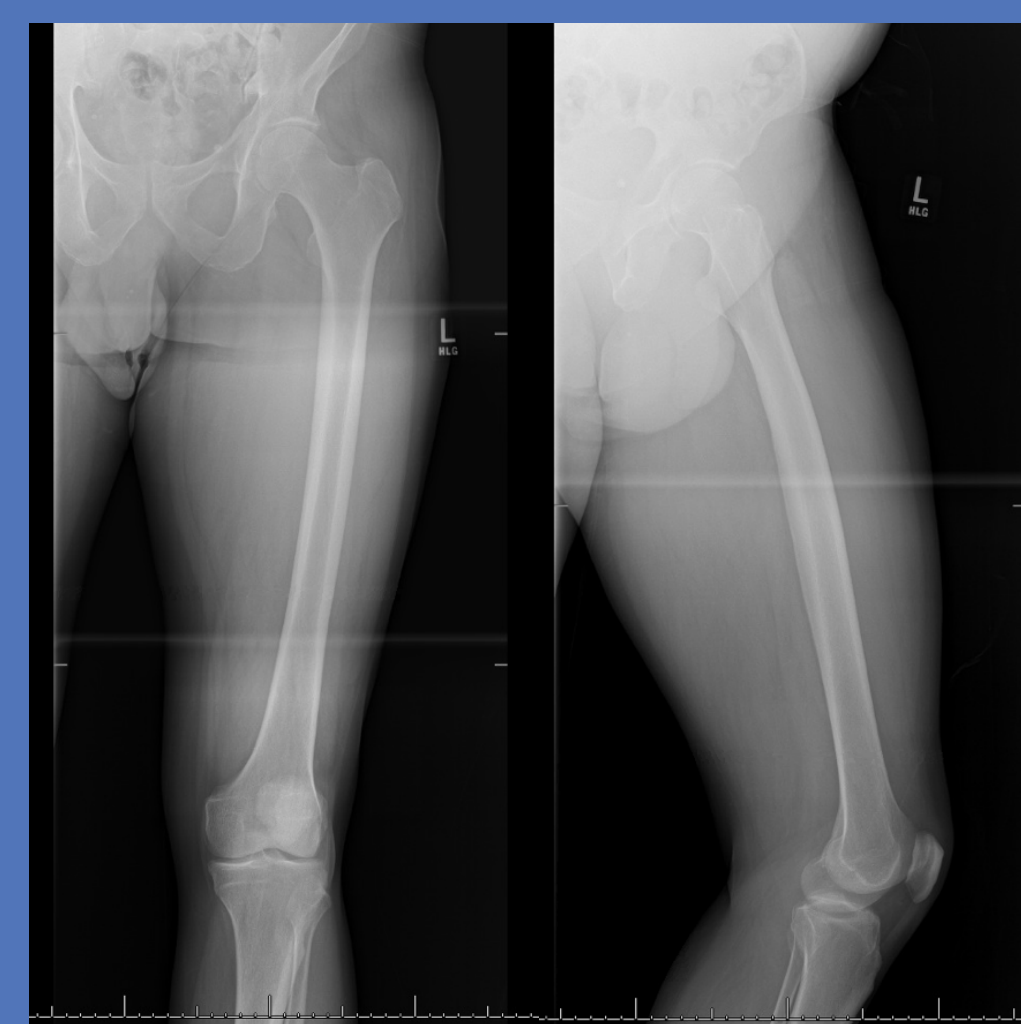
Anteroposterior and lateral radiographs of the left femur reveal no bony involvement nor calcifications of the left thigh mass.
